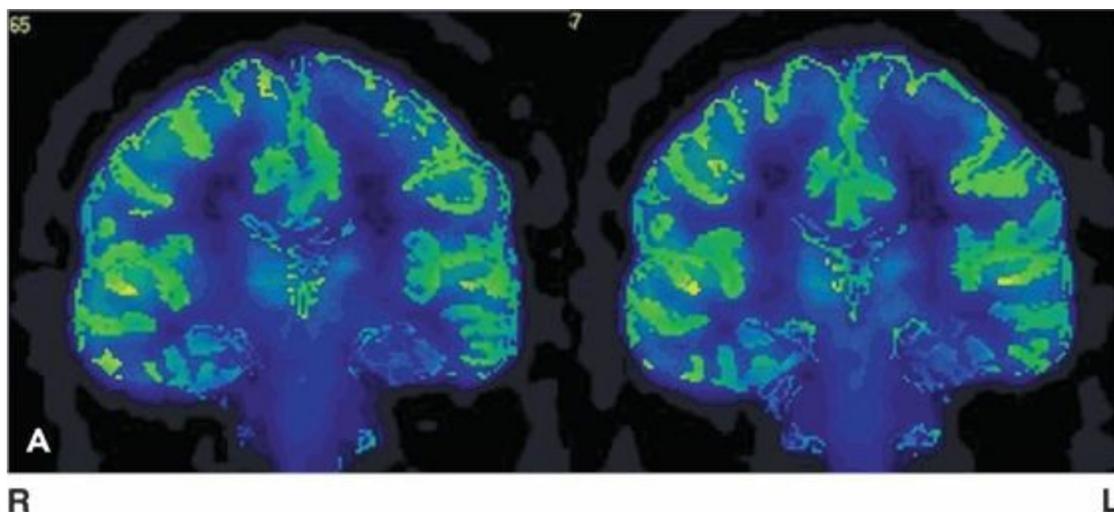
[¹⁸F]FDG-PET (upper row left) showing normal glucose uptake. [¹⁸F]FCWAY-PET (top row right) shows decreased binding in the left temporal lobe, most pronounced in the amygdala and hippocampus. Lower row are axial views of [¹⁸F]FCWAY PET in a normal volunteer. There is no ligand binding in the cerebellum, reflecting absence of 5HT 1A receptors in cerebellar tissue. Raphe nucleus ligand binding can be seen. Left image is the right brain. (Courtesy of Dr. William H. Theodore. National Institutes of Health, Bethesda, Maryland.)
